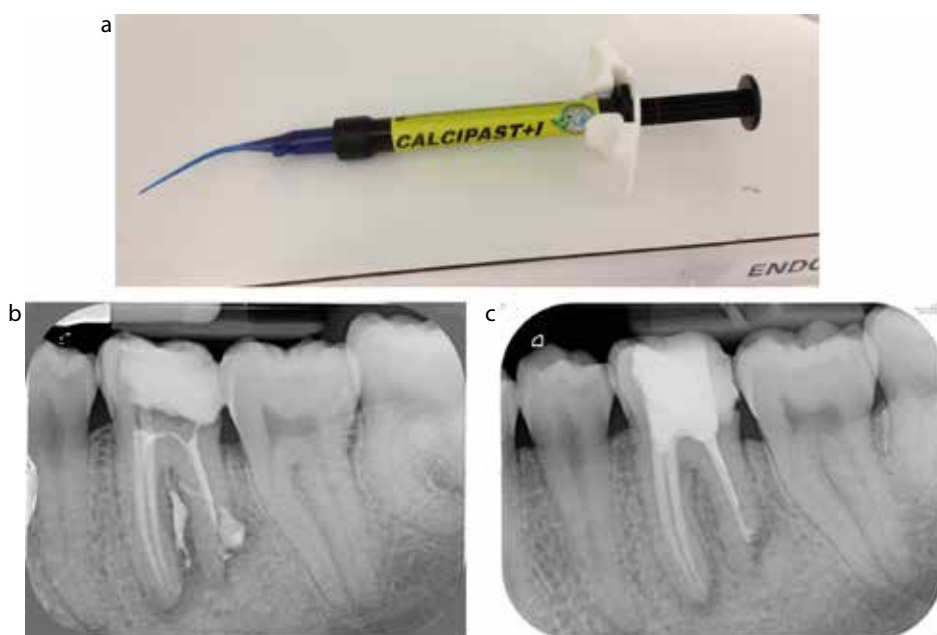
(a) *Calcipast+I* PD, Switzerland is calcium hydroxide and iodoform. The flexible cannula tip allows the placement of the dressing deep into the canal. (b) Following dressing the radiograph reveals *Calcipast* tracking through the periradicular tissues. (c) At 3 months following definitive obturation. Note the extensive healing already evident and full resorption of the extruded paste.
